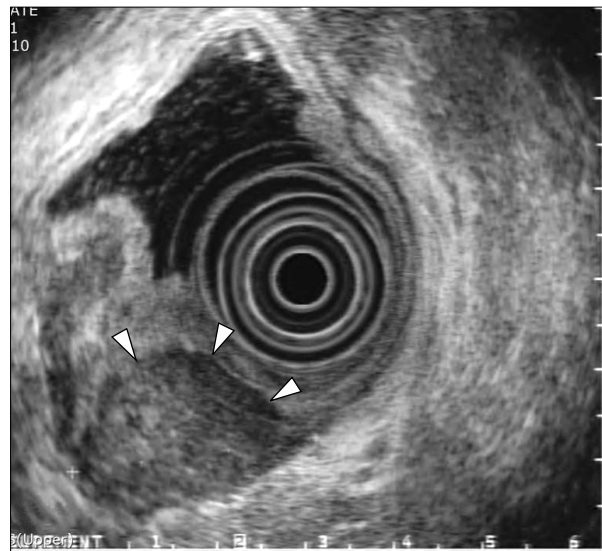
Endoscopic ultrasound revealed a 2.5-cm inhomogeneous semicircular mass (white arrows) originating from the muscularis propria that is surrounded by a demarcated hypoechoic rim.
